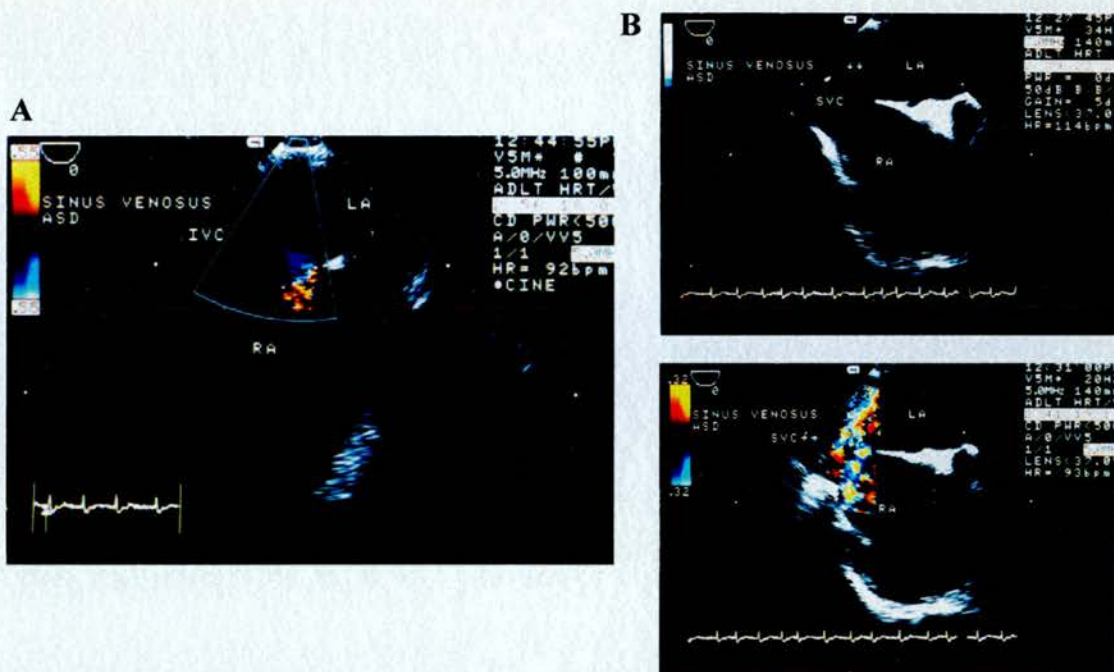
A seventy six year old male with sinus venosus atrial-septal defect; A, longitudinal view of the atrial septum, which highlights sinus venosus atrial-septal defect (colour Doppler flow) located in the superior fatty limbus of the atrial septum; B, transverse view of the atrial septum with the sinus venosus defect displaying in B-mode (upper panel) and visualised shunt by colour Doppler flow (lower panel). ASD, atrial-septal defect; LA, left atrium; RA, right atrium; SVC, superior vena cava; IVC, inferior vena cava
